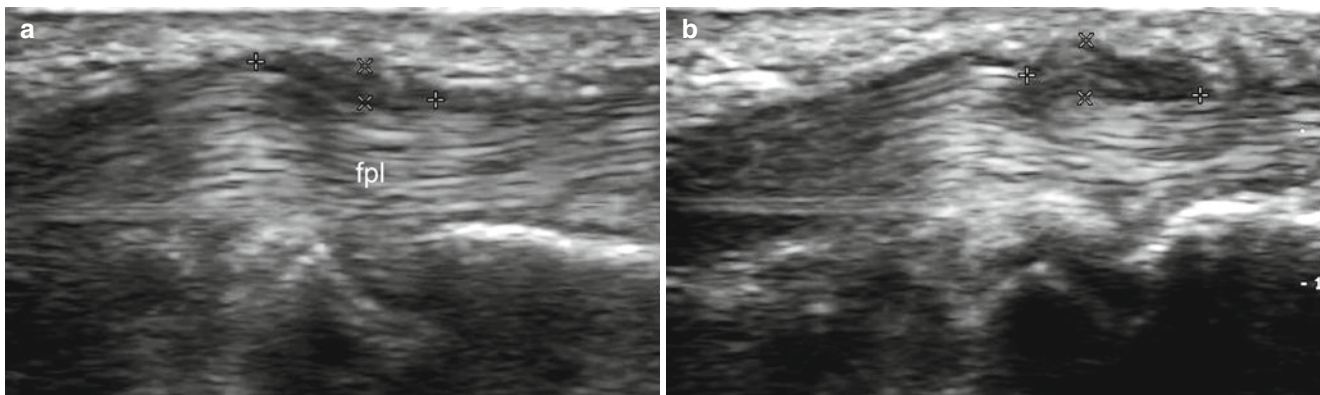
(a, b) Trigger finger. Grey scale ultrasound images (longitudinal views, left thumb; a: rest; b: under flexion). There is thickening of the A1 pulley (between markers) that is located on top of the flexor
